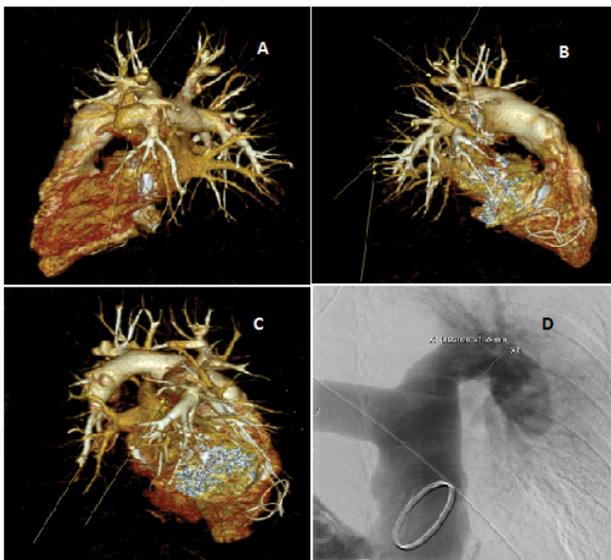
Cardiac CT and digital subtraction arteriography showing mycotic pulmonary artery aneurysm. CT reconstruction (A) shows multiple mycotic aneurysm of left and right pulmonary artery (arrows). Digital subtraction arteriography (B) shows huge mycotic aneurysm with 21 mm sized opening of left pulmonary artery (arrow).
